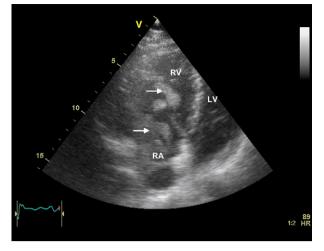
Transthoracic four-chamber view demonstrating a worm-like free-floating mass (arrow) in the right atrium with protrusion in the enlarged and hypertrophied right ventricle during diastole (four-chamber view RVED 5.1 cm, parasternal long-axis RVED 3.3 cm, RV free wall 0.6 cm). RA = right atrium, RV = right ventricle, LV = left ventricle.
